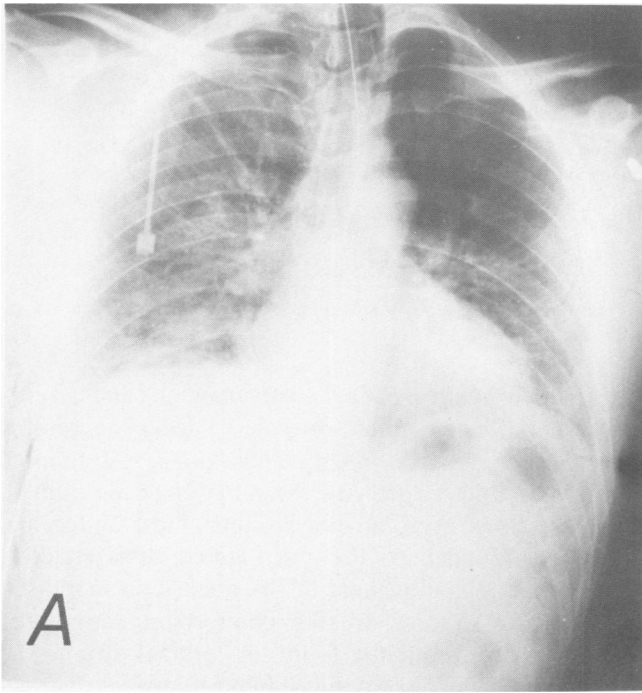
Admission chest roentgenogram in a patient with bullet wound of the right chest and the bullet imbedded in the left axilla. No evidence of mediastinal widening or pneumomediastinum is noted.
